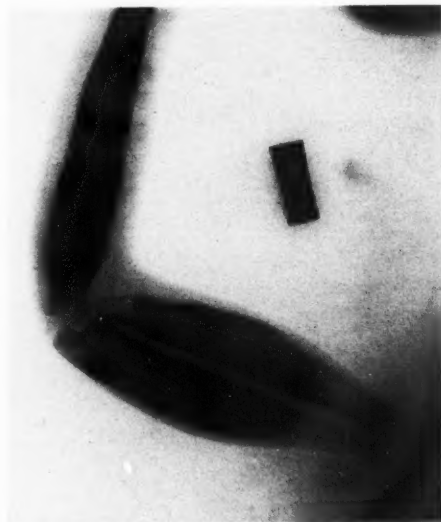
Roentgenogram showing a bone dystrophy in a white male, aged seven, in which there is new bone formation restricted to the diaphyseal regions. The new bone formation also involves the skull, occluding various foramina. This is an unclassified form of juvenile bone dystrophy.
